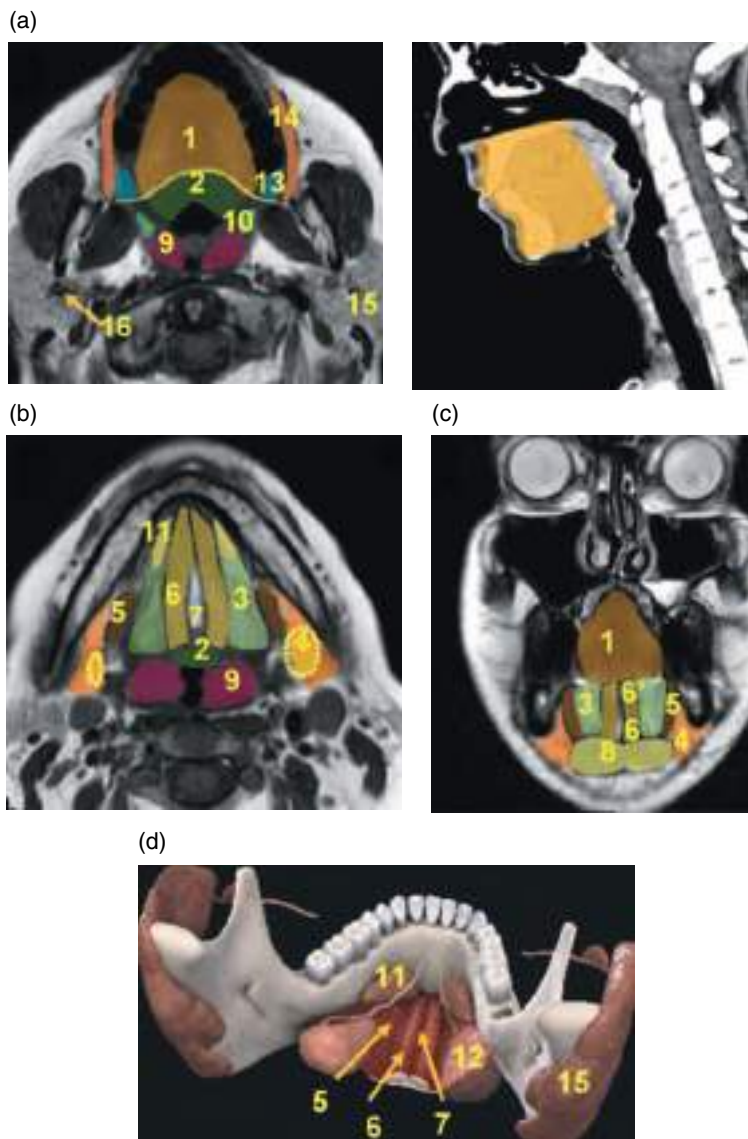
Oral cavity (yellow area in the sagittal noncontrast CT image, on the right). (a) Axial T1-weighted MRI at the level of the palate (yellow area in the sagittal noncontrast CT image, on the right). (b) Axial view at the level of the floor of mouth. (c) Coronal T1-weighted MRI. (d) Volume rendering of the floor of mouth with the salivary glands. 1, free edge of the tongue; 2, base of the tongue; 3, sublingual space; 4, submaxillary space; 5, mylohyoid muscle; 6 and 6', genioglossus-geniohyoid complex, root of the tongue; 7, lingual septum; 8, anterior belly of the digastric muscle; 9, palatine tonsil; 10, anterior tonsillar pillar (palatoglossus muscle); 11, sublingual gland; 12, submandibular glands (encircled by yellow dots); 13, retromolar trigone; 14, buccinator muscle; 15, parotid gland; 16, retromandibular vein.
